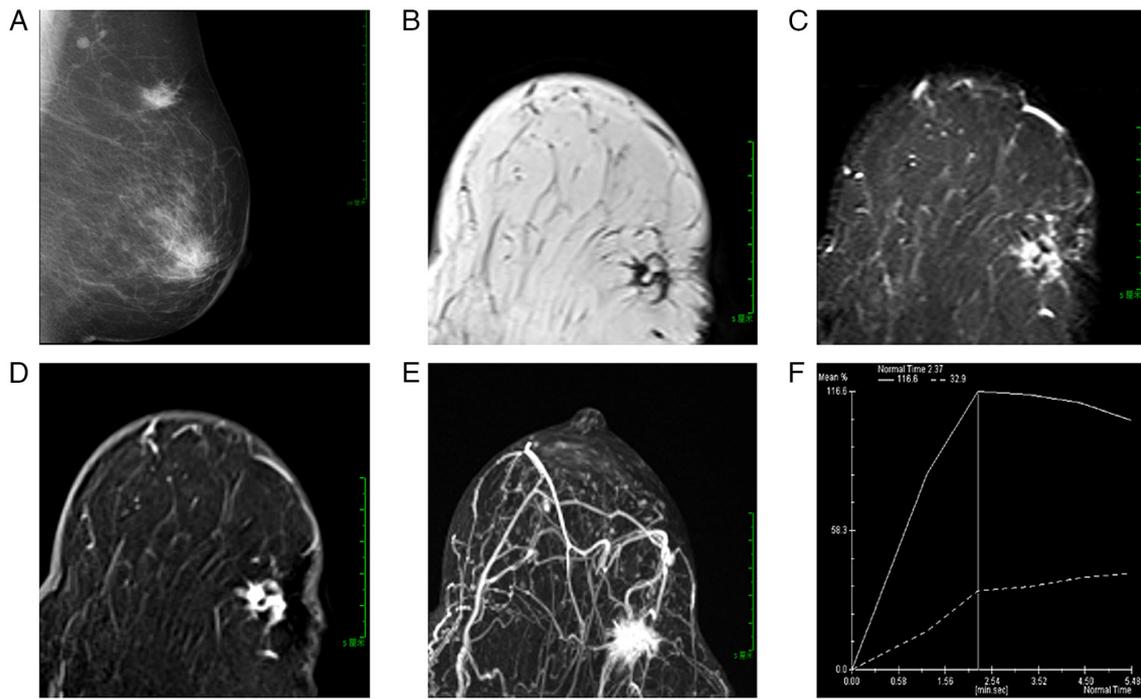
(A) The mammographic mediolateral oblique view reveals an irregular high-density mass in the upper outer quadrant of the left breast, with indistinct, spiculated margins. (B) Axial T1-weighted MRI exhibits an irregular mass in the upper outer quadrant of the left breast with indistinct, spiculated margins. The lesion exhibits low signal intensity with small focal areas of high signal intensity within. (C) Axial fat-suppressed T2-weighted MRI demonstrates slightly high signal intensity within the mass, with small focal areas of low signal intensity. These areas are lower in signal intensity than the surrounding fat, displaying the characteristic 'black hole sign'. (D) Axial post-contrast MRI exhibits heterogeneous enhancement of the mass with patchy non-enhancing areas. (E) Maximum intensity projection reveals slightly increased vascularization of the mass. (F) The time-signal intensity curve demonstrates a washout pattern.
